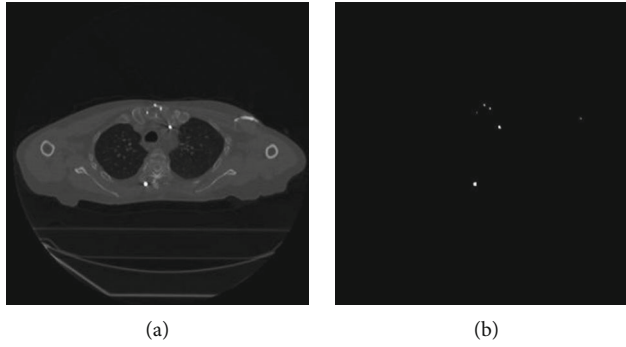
The original CT image and segmented high density image.
